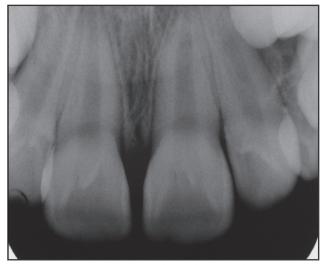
One-year postoperative periapical radiograph after surgical excision of pyogenic granuloma and pedicle grafting.
